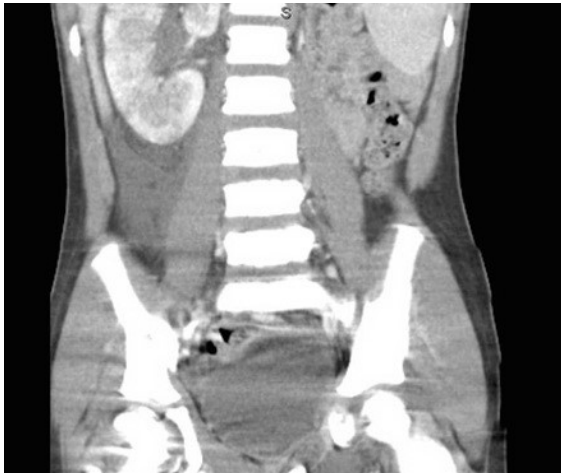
Computed Tomography of the Abdomen – Interpreted as pyelonephritis of the right kidney.
